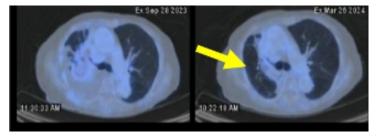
The latest PET-CT scan noted a further decrease in size and FDG uptake of the lobulated soft tissue mass in the right upper lobe now measuring approximately 1.8 x 3.0 cm (previously 3.5 x 3.1 cm) 10 months since starting treatment. (pointed)
